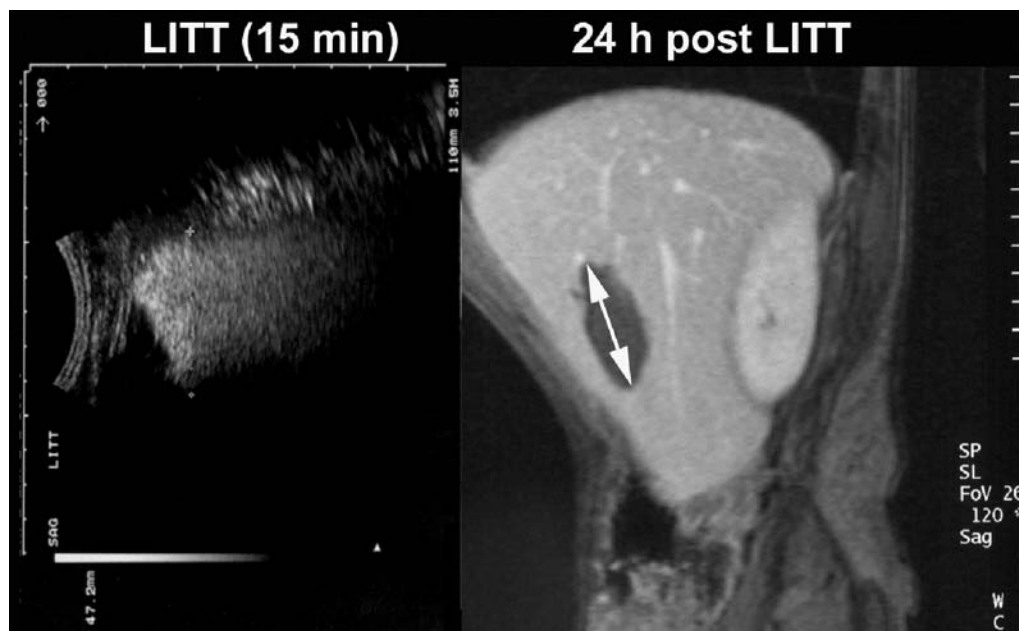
Ultrasound during laser therapy of a liver metastasis and corresponding MRI, both on sagittal orientation. The hyperechogenic area visualized on US is provoked by nitrogen bubbles that occur during tissue heating. US tends to overestimate ablation zone, as demonstrated on postinterventional MRI
